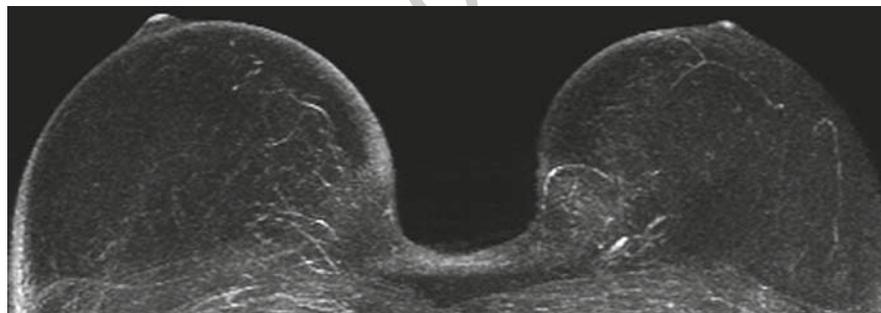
MRM-BI-RADS 1 in superior quality MRI – do we need more diagnostics? High resolution MRI of the breast without any motion artifact (MRI artifact type I) demonstrating no parenchymal enhancement after administration of contrast material (MRI density type I) and no enhancing lesion (MRI-BI-RADS
